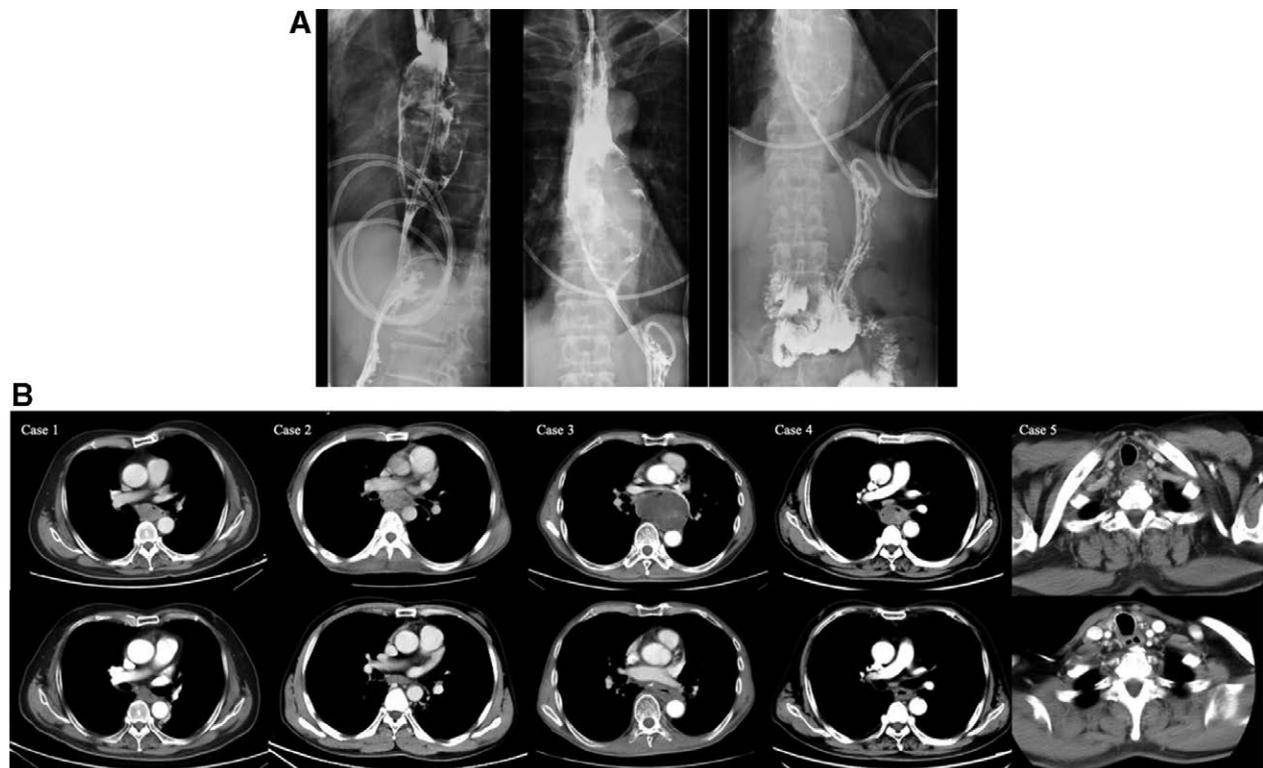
Radiographic assessment of the tumor by esophagus barium meal and computed tomography (CT). (A) Esophagography shows that the middle and lower part of the esophagus is obviously expanded and the mucosal folds is interrupted. The irregular filling defects and irregular niches can be seen. The barium flow is narrowly passed through the tube. (B) The CT scan demonstrates irregular thickening of the esophageal wall and narrowing of the lumen of the thoracic esophagus in the 5 patients received curative or neoadjuvant radiotherapy, and relatively apparent relief after radiation treatment or chemoradiotherapy 1 to 3 mo later.
